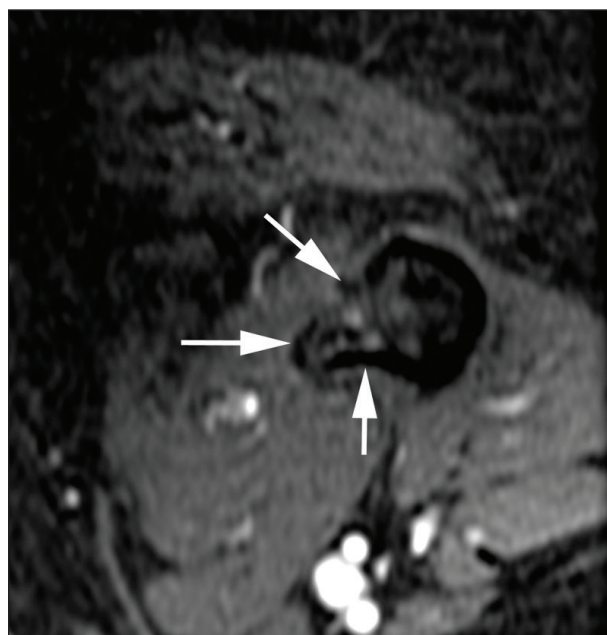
Axial spoiled gradient echo postcontrast MRI demonstrated black box appearance of hypoenhancement along the bone/soft tissue interface (arrows) following MR-guided focused ultrasound of a colon cancer metastasis to the proximal left femur.
